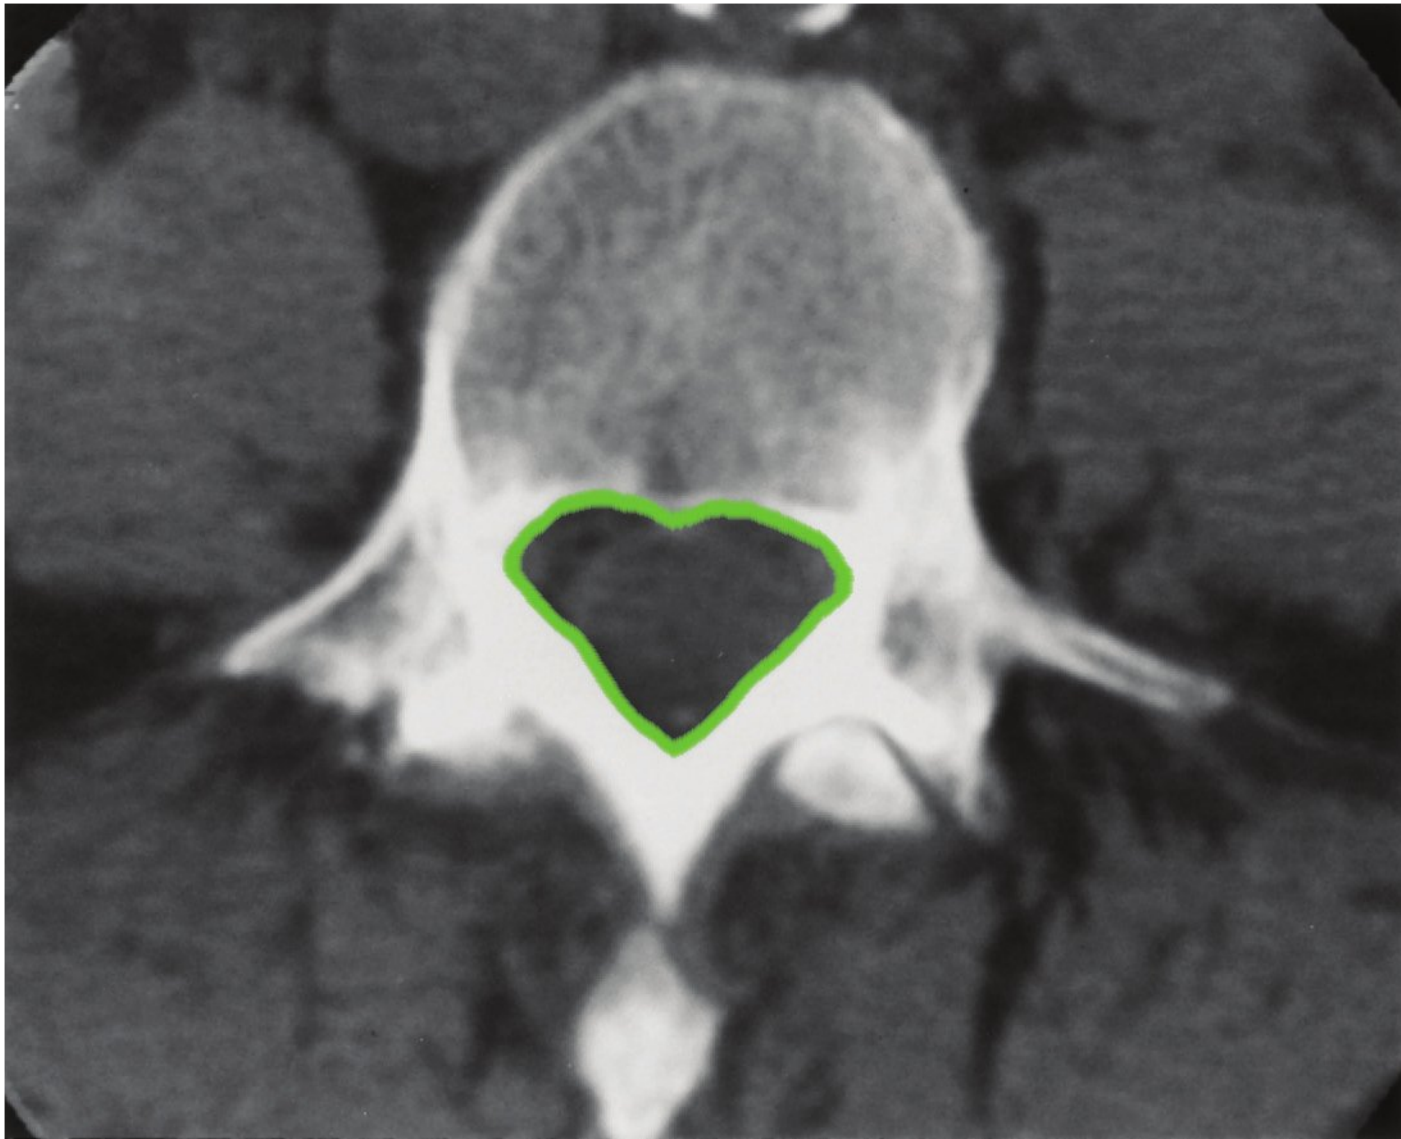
Axial cut (computed tomographic scan) at L4 that demonstrates the pedicles and bony anatomy. Note: the thecal sac can be visualized as well.
